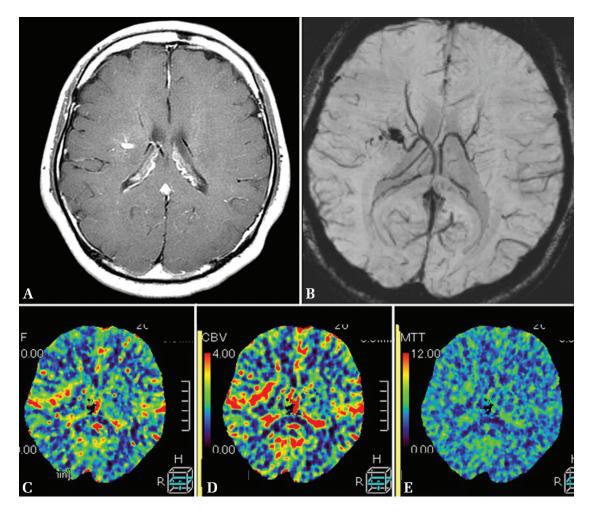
A representative case showing the potential relationship between venous congestion around developmental venous anomaly (DVA) as a trigger of cavernous malformation (CM) formation and bleeding. A 33-year-old man complaining of sudden onset of severe headache presented with a slight left hemiparesis. In this case, CM that was associated with DVA was considered to be the cause of hemorrhage. A perfusion study reveals venous congestion around CM in the territory of DVA. (A) Gadolinium-enhanced gradient-echo T_1 -weighted MRI showing DVA in the right corona radiata. (B) Susceptibility-weighted imaging showing CM in the right corona radiata, located within the territory of DVA. CT-perfusion image showing an increase of cerebral blood flow (C) and cerebral blood volume (D), and prolongation of mean transit time (E), which is compatible with venous congestion.
